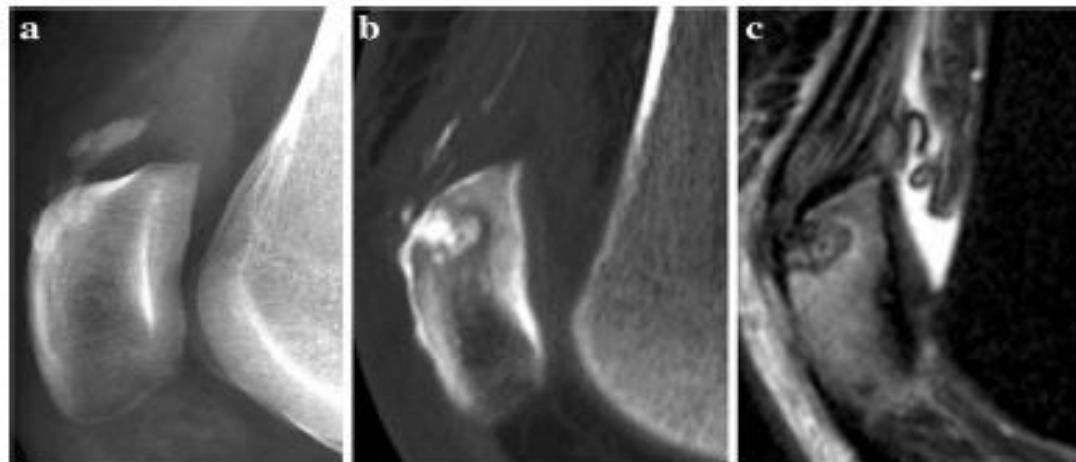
Calcific intraosseous extension into the patella (courtesy of O. Hauger). a A radiograph of the knee shows an amorphous calcium deposit in the lower end of the quadriceps tendon. b A few weeks later, during an attack of acute pain, a CT scan shows that the tendonous
